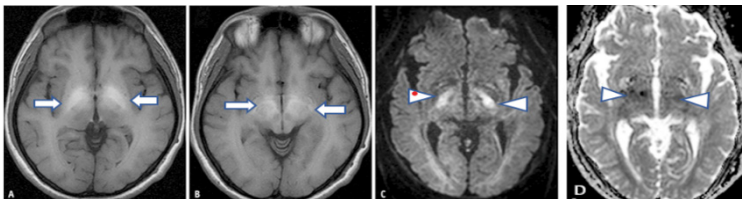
In a 44-year-old patient with hepatic encephalopathy, A) and B) show hyperintensities in the globus pallidus and cerebral peduncles on T1-weighted images due to manganese accumulation (arrowheads), while C) and D) demonstrate diffusion restriction in the thalamus (arrowheads). (13)
